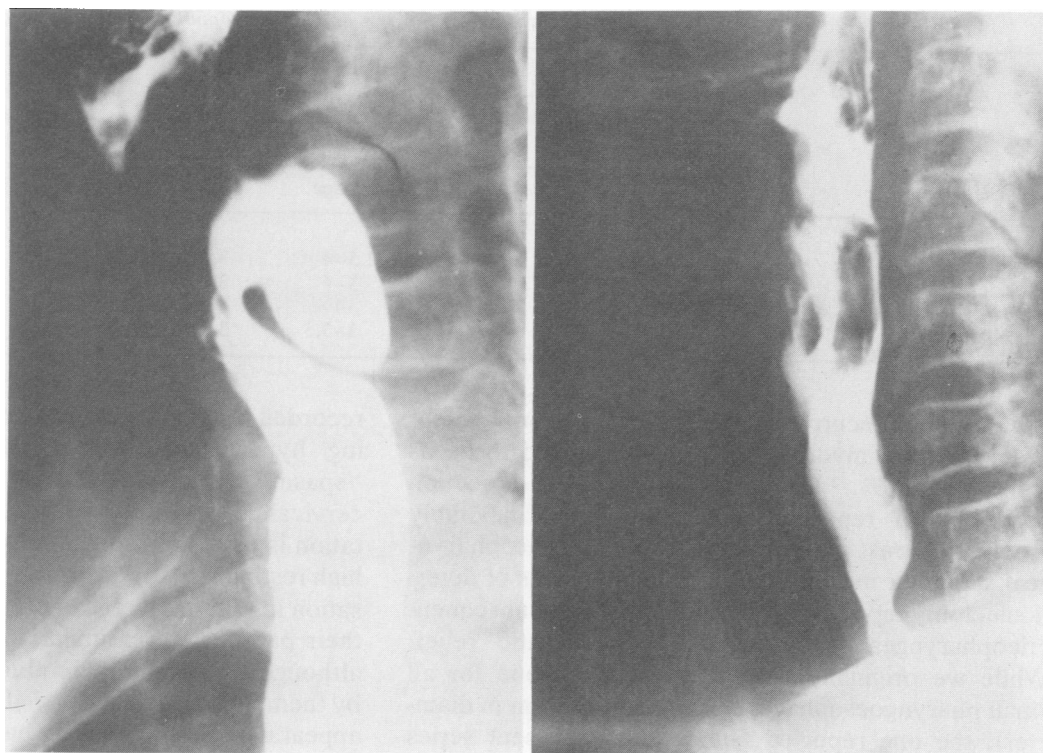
Preoperative (left) and postoperative (right) esophageal roentgenograms in patient with pharyngoesophageal diverticulum pictured in Figure 1.
